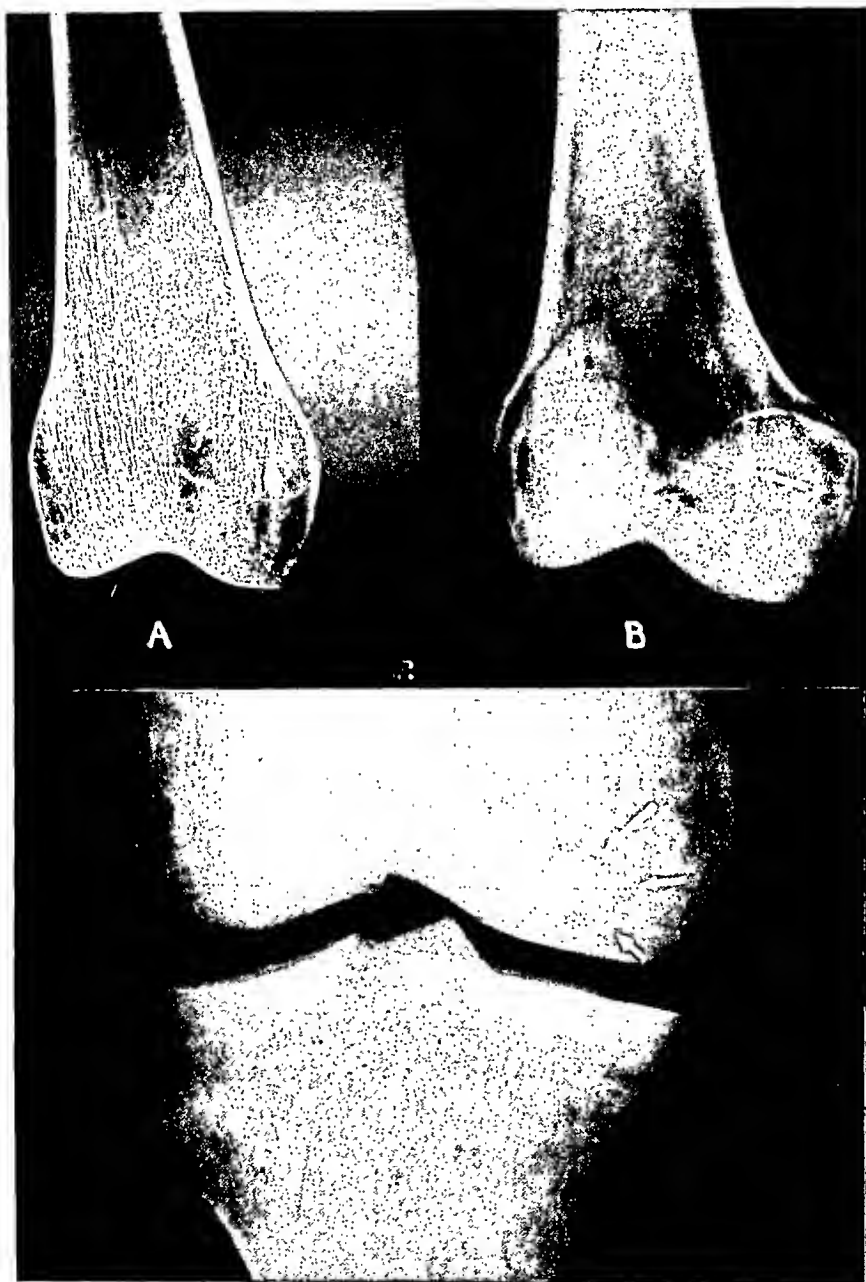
A (above). Roentgenogram of a thin section of the distal end of a macerated femur showing a circumscribed area of sclerosis, a compact island.
